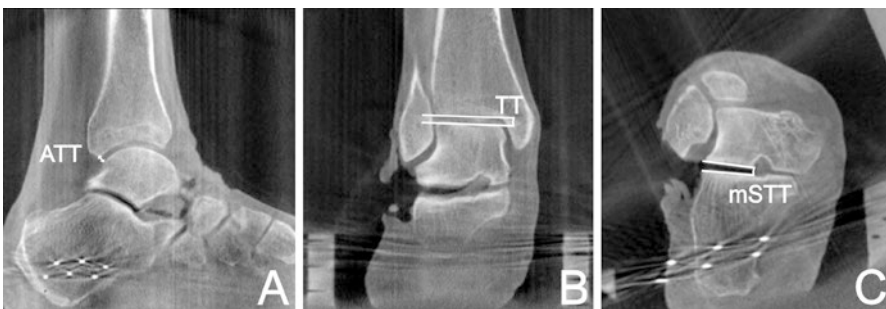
Measurements performed on single computed tomography (CT) images (discrete calcaneofibular ligament [CFL] dissection). (a) Lateral view showing the measurement of the anterior talar translation (ATT). (b) Anteroposterior (AP) view showing the measurement of the tibiotalar tilt (TT). (c) 30/40-degree Broden view (middle plain) showing the measurement of the subtalar tilt (STT) [1]
